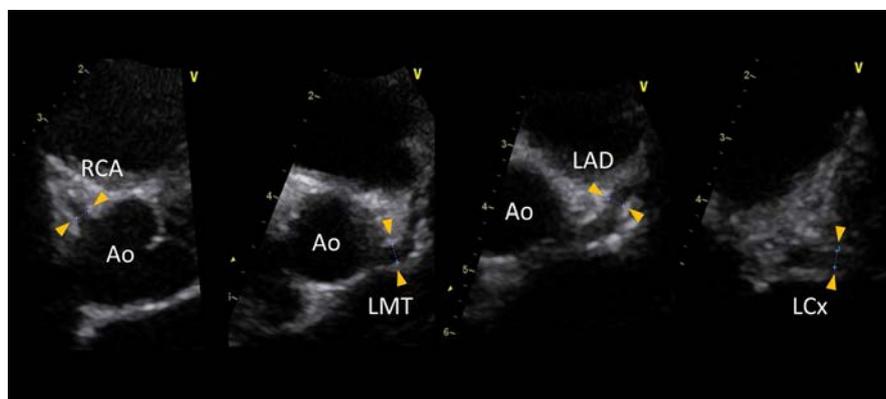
Echocardiogram of the patient, performed on day 4. Slight dilatation of the LMT was recognized. No evidence of valve regurgitation and cardiac dysfunction was observed. Each measured value was as follows: RCA (seg1): 2.2 mm ($Z = 0.75$), LMT (seg5): 3.4 mm ($Z = 2.91$), LAD (seg6): 2.6 mm ($Z = 1.90$), LCx (seg11): 2.5 mm ($Z = 2.08$). Abbreviations: Ao, aorta; LAD, left anterior descending artery; LCx, left circumflex artery; LMT, left main trunk; RCA, right coronary artery; Z, Z score
